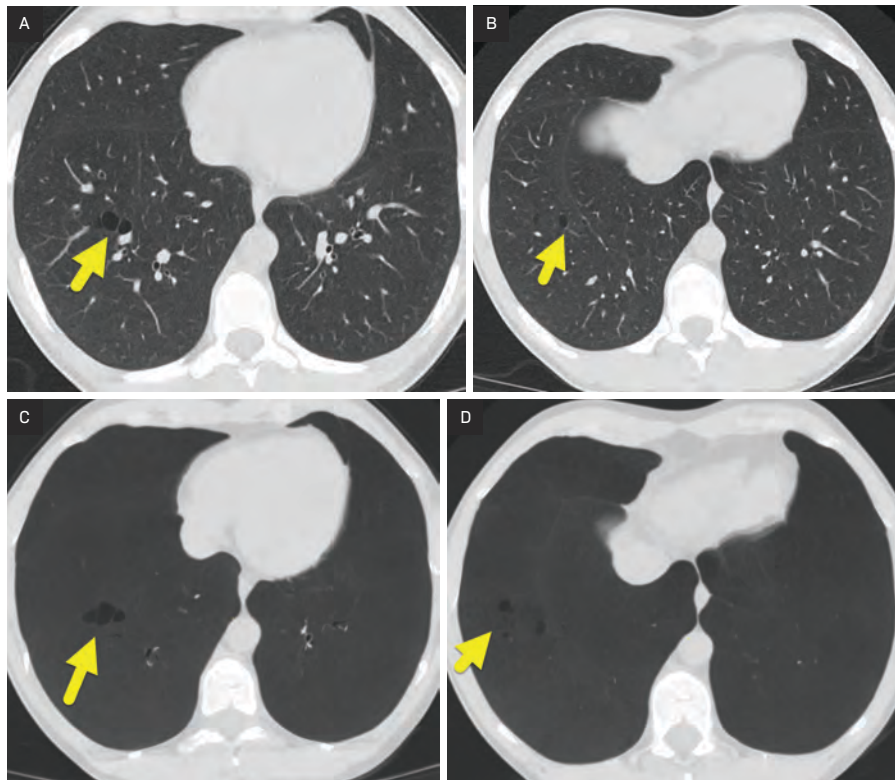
(A, B) Sequential images from chest CT performed 12 years later showing that the small cysts (arrow) have increased in size and number. (C, D) Minimum intensity projection images at the same levels highlighting the extent of the small cysts.
